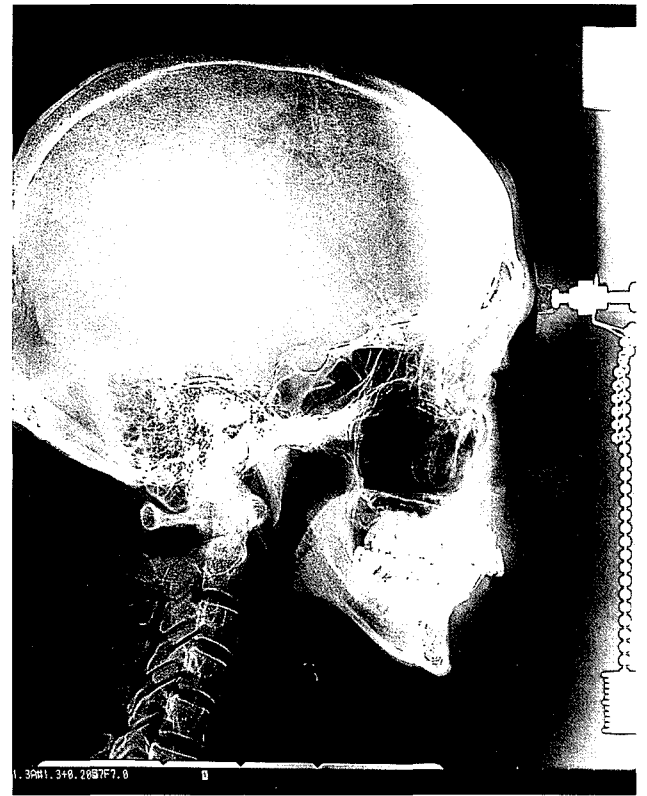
M4 Digital lateral cephalometric radiograph is seen.
